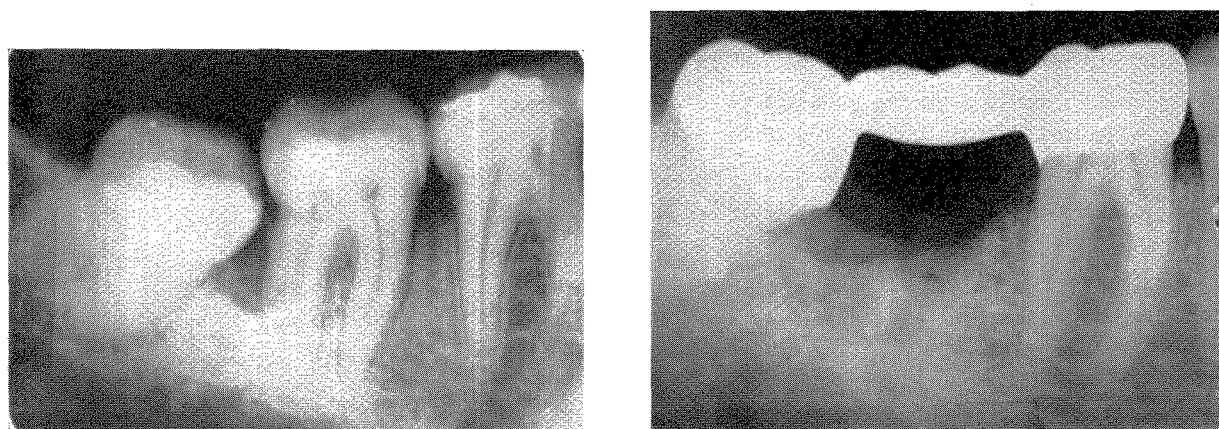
In November, 1950, the lower second molar was removed in an effort to control the advanced periodontal disease. A fixed bridge splint was inserted as the right radiograph reveals. Low cusps and a well-coordinated interocclusal relationship augmented the healing process.
